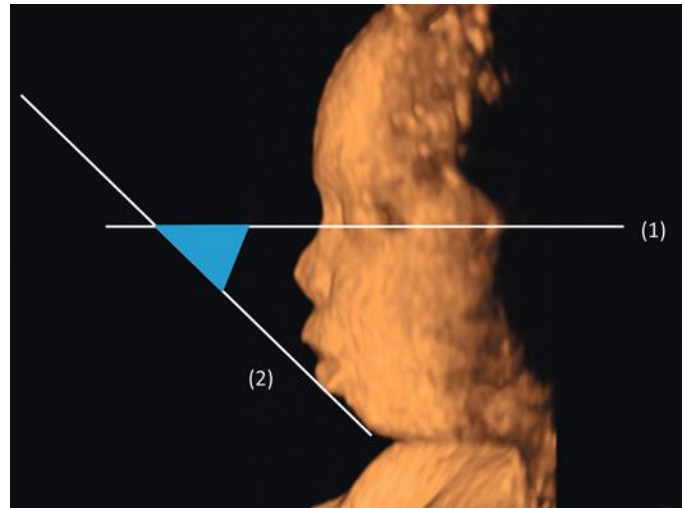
Inferior facial angle obtained from a sagittal view of the fetal face. The angle is formed by a reference line (1), orthogonal to the vertical part of the forehead at the level of the synostosis of the nasal bones, and the profile line (2), joining the tip of the mentum to the anterior border of the more protruding lip. (From Mittermayer C, Blaicher W, Brugger PC, et al: Foetal facial clefts: prenatal evaluation of lip and primary palate by 2D and 3D ultrasound. *Ultraschall Med* 25:120-125, 2004.)
